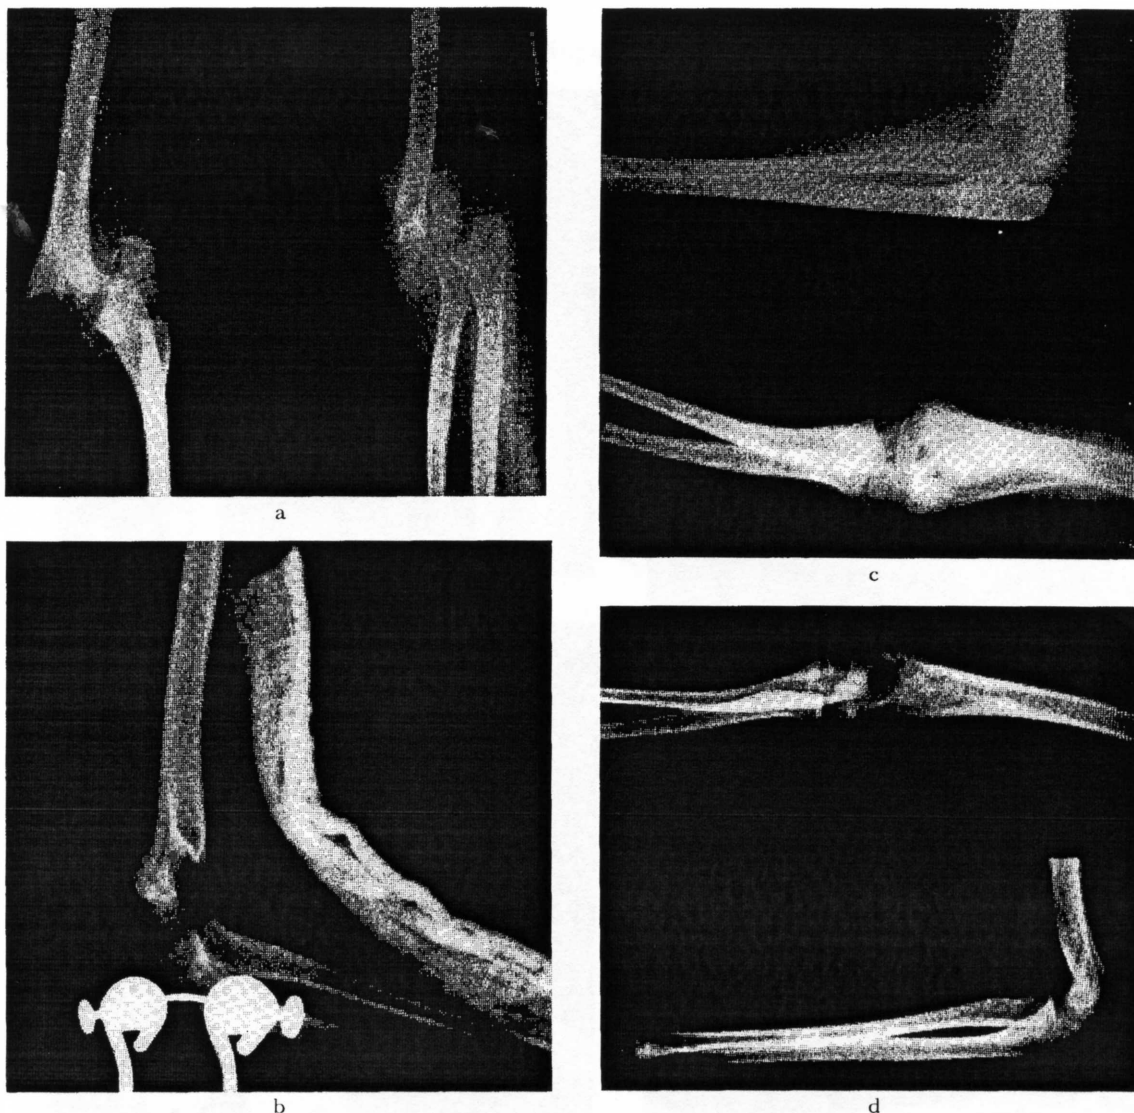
a, Prereduction film showing severe displacement. b, Closed manipulative reduction unsuccessful and olecranon skeletal traction instituted. This is first check x-ray film after start of skeletal traction. Present position not acceptable. c, This patient had 1 closed manipulative reduction and 2 further manipulations under anesthesia after skeletal traction instituted. This is position when cast was removed at 6 weeks. d, X-ray appearance 4 years later. Range of motion and physical appearance completely normal.
